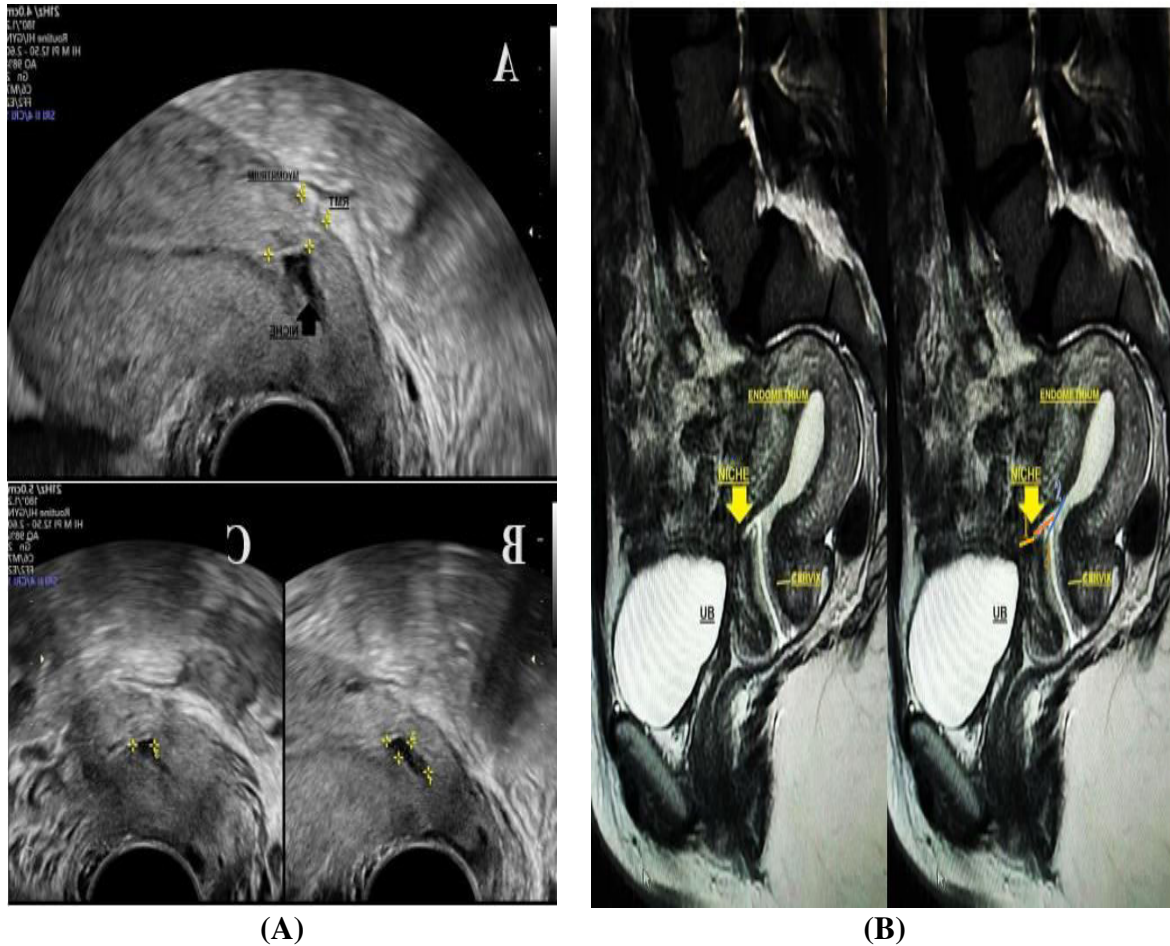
(A) TVUS show TVUS of RVF uterus with myometrium defect at the site of previous cesarean delivery with residual myometrium thickness a)1. residual myometrial thickness 3.2mm, 2. AMT 10.9mm, b)1. Width 16.3mm, 2. Depth 6.9mm, c)3. Length 6.5mm, (B) MRI revealed midsagittal T2 WI of pelvic MRI revealed RVF uterus with rectangular shaped myometrium defect directed anteriorly 1.RMT 3.7mm, 2.width 17.3mm, 3.depth 8mm
